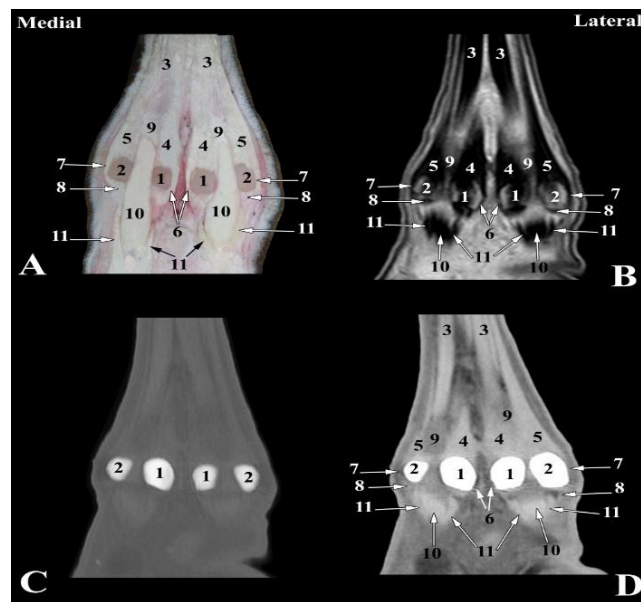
Dorsal images of right hind fetlock joint of camel at the level of proximal sesamoid bones (Level 4 as indicated in Fig. 1). A- Dorsal anatomical section; B- Magnetic resonance image; C- Bone window computed tomography image; D- Soft tissue window computed tomography image: 1- Axial sesamoid bones; 2- Abaxial sesamoid bones; 3- Inter-osseous muscle; 4- Axial limbs of inter-osseous muscle; 5- Abaxial limbs of inter-osseous muscle; 6- Axial collateral sesamoidean ligaments; 7- Abaxial collateral sesamoidean ligaments; 8- Straight sesamoidean ligaments; 9- Manica flexoria; 10- Deep digital flexor tendon; 11- Superficial digital flexor tendon.
